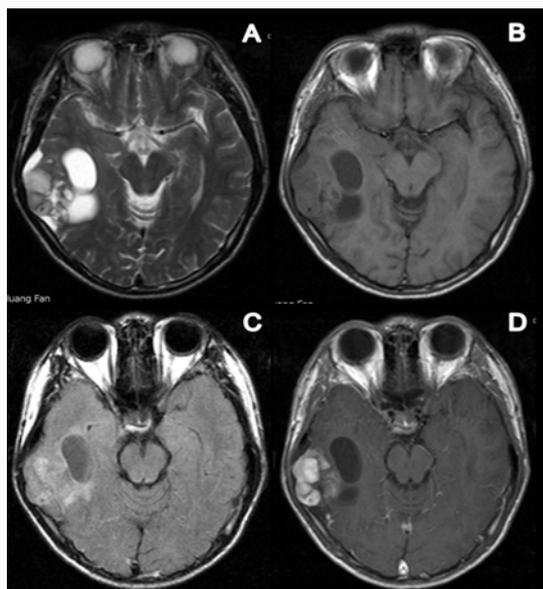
Male, 16 years-old, admitted to the hospital after repeated mouth convulsions for 3 months. Cystic lesion with a nodule pattern of PXA. The lump located in the right temporal lobe shows several cystic lesions with large mural nodule. (A) Unenhanced axial T2-weighted image of slightly hyperintense lesions with a mural nodule adjacent to the leptomenigeal surface. (B) Unenhanced axial T1-weighted image of isointense, hypointense lesions. (C) FLAIR-weighted images of slightly hyperintense lesions. (D) Obvious contrast enhancement of mural nodule, no enhancement of the capsule wall on the axial enhanced T1-weighted image, and the mural nodule is significantly enhanced compared with the solid components of the previous case.
